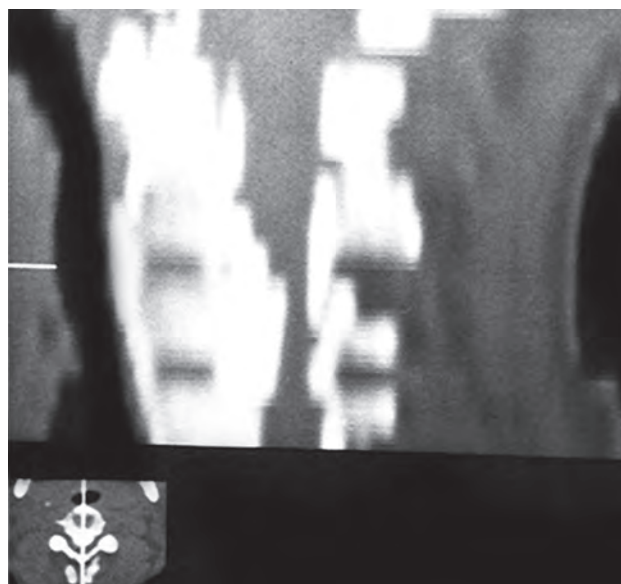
Sagittal CT showing OPLL and calcified ligamentum causing severe compression of the cord
